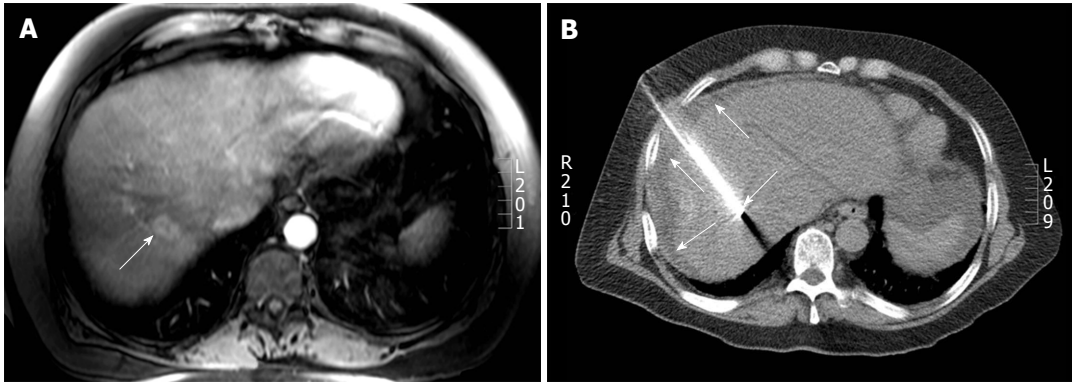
Computed tomography guided radiofrequency ablation in a 56-year-old lady with colorectal liver metastases. A: Axial post gadolinium T1 weighted magnetic resonance image shows a 2.7 cm (arrow) hepatic dome metastases; B: The radiofrequency ablation was performed with the patient in supine position and needle placement through the anterolateral intercostal approach. Hydrodissection was performed in this patient (arrows).
